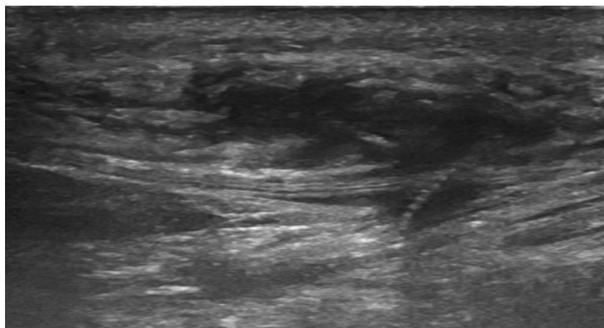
Ultrasound image of retained PNS lead fragment with surrounding hyperemia
